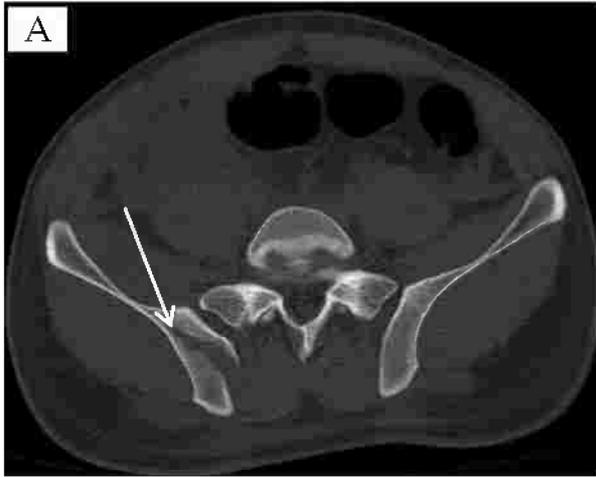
35 years old female with history of road traffic accident, axial bone window CT in (A,B,C) and VR in (D,E,F,G) show widening of the symphysis pubis (arrow head in B,C,D) , right iliac wing fracture (long arrow in A,) reach to right SI joint that showed diastasis (small arrow in A,D). There is fracture in both inferior and superior right pubic rami (arrow in C and thick arrow in D,E,F). Fragment is seen in D (Green arrow).
